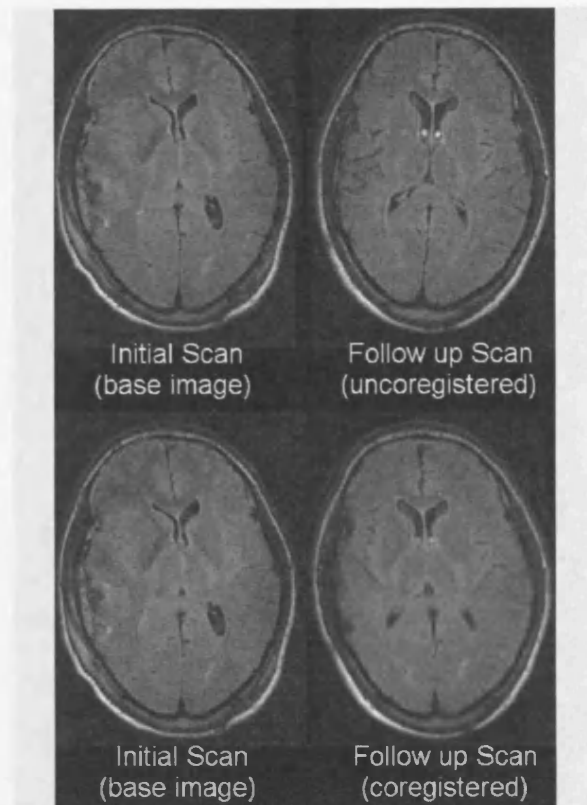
Affine coregistration. Top image pair showing initial and follow up MRI scans from a patient, these images are not aligned. The bottom image pair are the same images except the follow up scan is has now undergone a rigid body coregistration and the images are now aligned.
